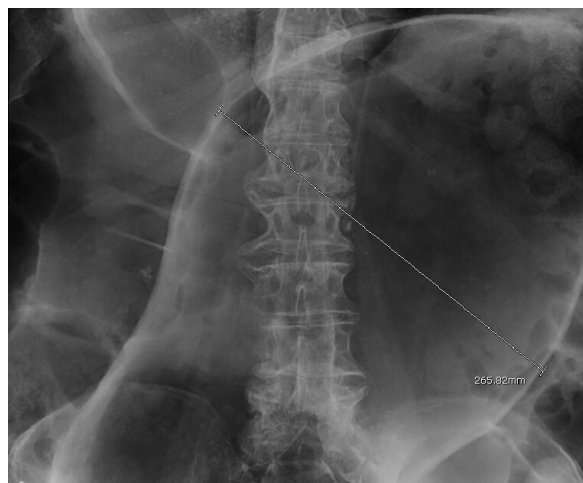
Abdominal X-Ray showing a large air-filled structure oriented from the left upper quadrant to the right lower quadrant measuring up to 26 cm
